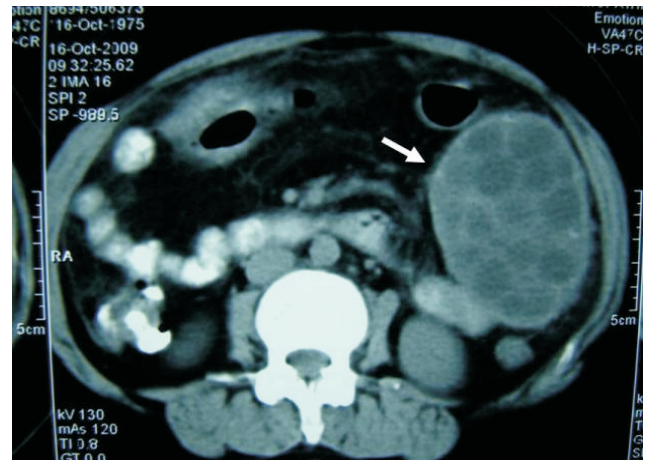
CT scan showing multiple hypochoic lesions in the spleen
